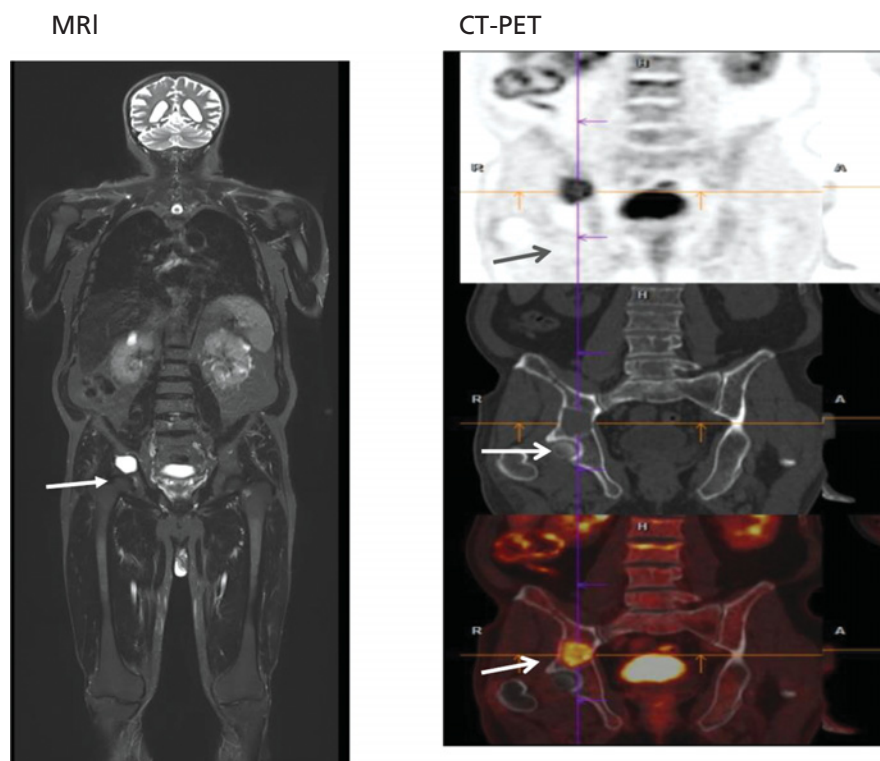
MRI and PET/CT in a myeloma patient. The arrows show a myeloma lesion in the lower part of the right iliac bone. The T2 weighted MRI shows a hyperintense image (left) and an active lesion at FDG PET/CT is confirmed (right).
